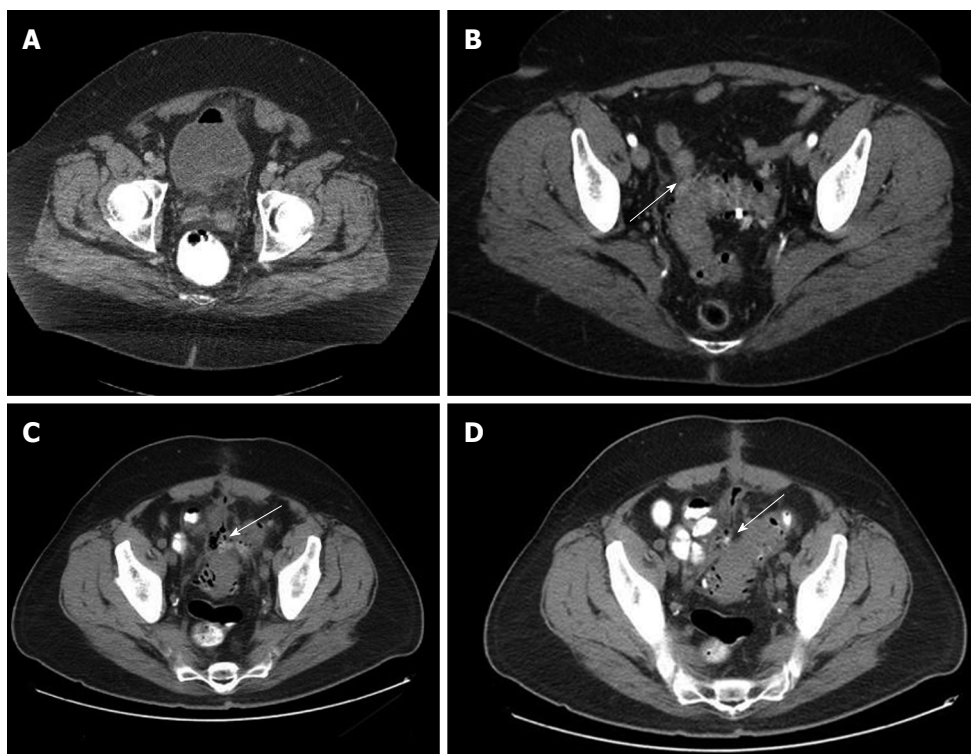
Fistula. A: Colovesical fistula as indicated by the presence of air in the bladder. This patient had symptoms and other CT findings consistent with sigmoid diverticulitis; B: Sigmoid diverticulitis and colovaginal fistula. This patient had undergone previous hysterectomy and complained of feculent discharge from her vagina. CT scan indicated inflamed sigmoid with adherent small bowel loop (arrow). The small bowel loop could be successfully separated from the sigmoid at the time of laparoscopic sigmoidectomy. There was no evidence of coloenteric fistula; Sigmoid diverticulitis with colocolic fistula (arrows) (C and D) (courtesy of Dr. Ravi Pokala Kiran, Department of Colorectal Surgery, Digestive Disease Institute, Cleveland Clinic, Cleveland, Ohio, USA).
